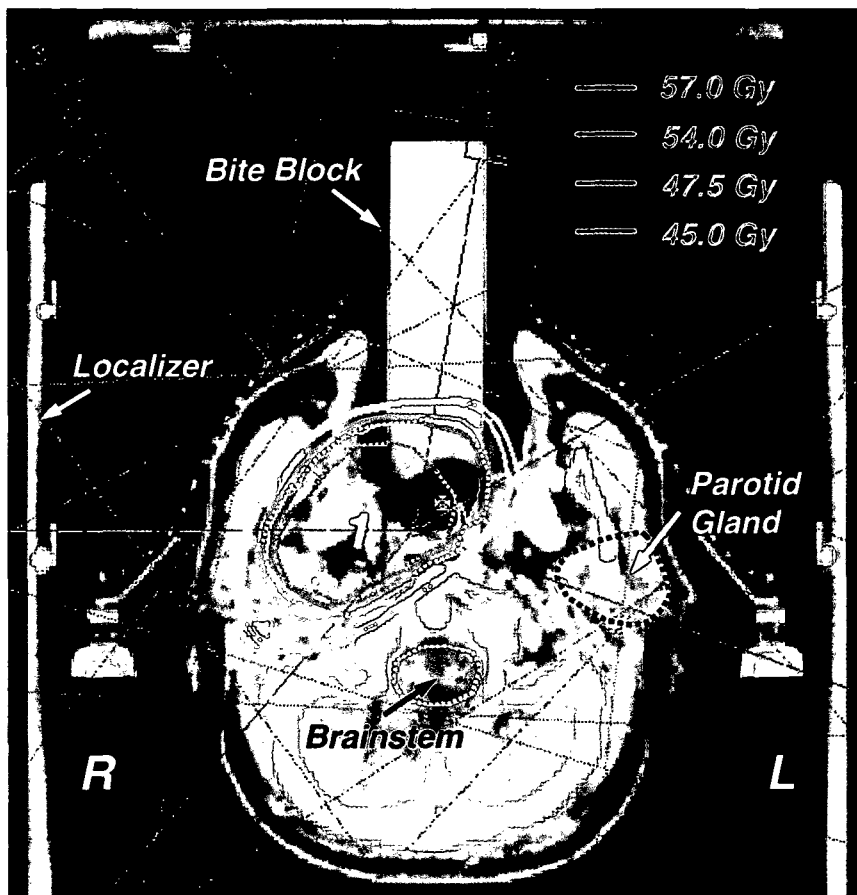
CT slice 5 cm above the isocenter. Beside the tumour (1) as single target volume, brainstem and left parotid gland are delineated as organs at risk. The patient was positioned in a head-and-neck fixation mask system with an integrated localizer box providing stereotactic isocenter coordinates. To immobilize tongue and mandible, a bite block was inserted in the oral cavity and fixed to the mask.
